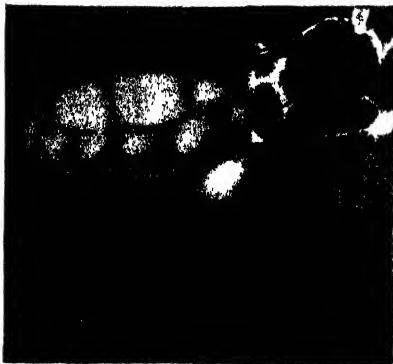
Dental (root) cyst expanding the alveolus. Inset, the radiograph.
